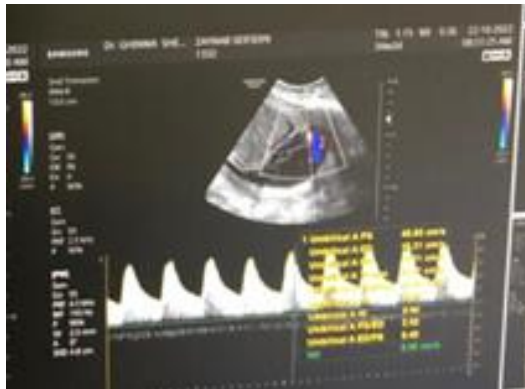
Umbilical artery doppler flow.
